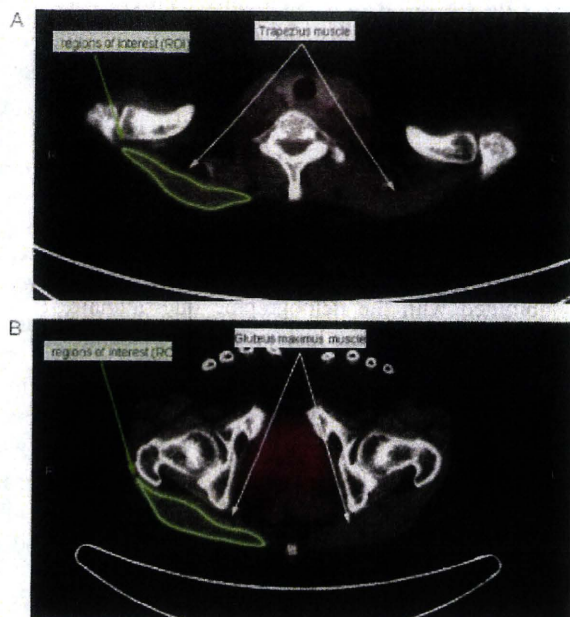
A, Region of interest (ROI) set on the trapezius muscle (study muscle) in positron-emission tomography/computerized tomography (PET/CT) cross-sectional image. B, ROI set on the gluteus maximus muscle (control muscle) in a PET/CT cross-sectional image.
